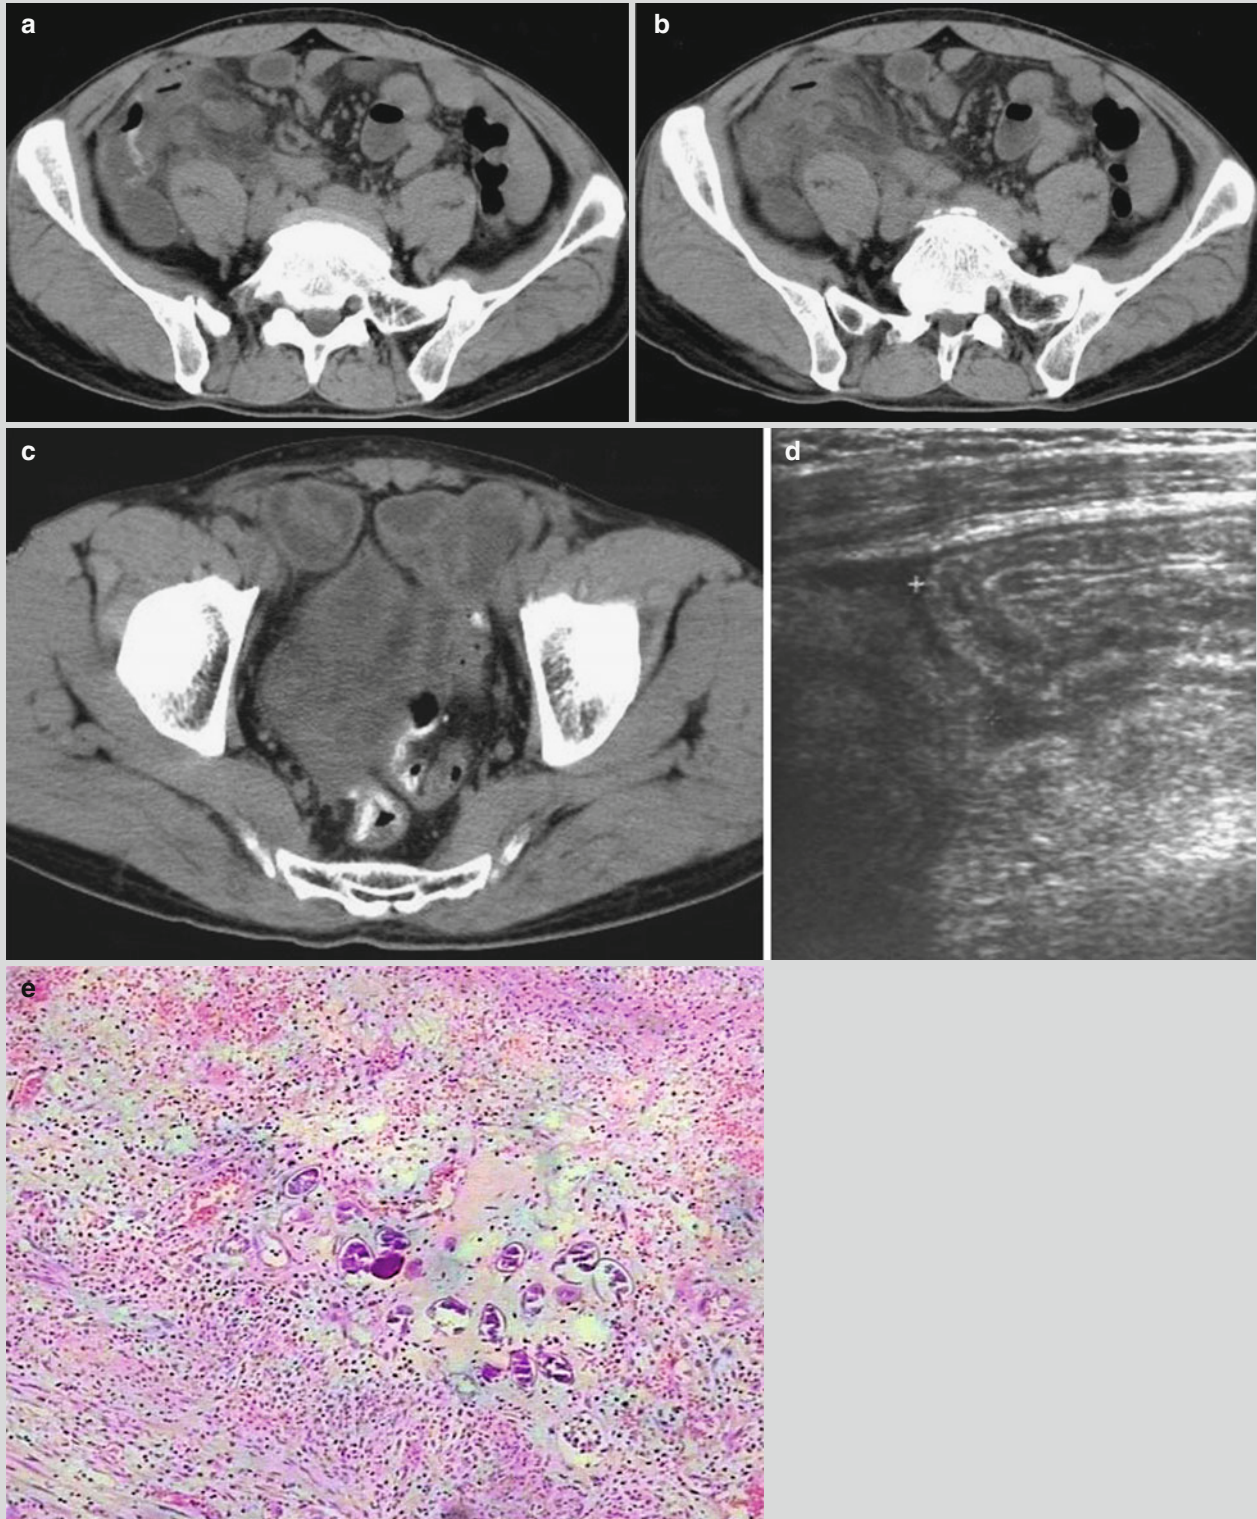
Intestinal schistosomiasis. (a, b) Plain CT scanning demonstrates ileocecal swelling, blurry surrounding fat space, and fine strips of calcification at the intestinal wall. (c) Calcification is demonstrated at the intestinal wall of rectum and sigmoid colon. (d)
